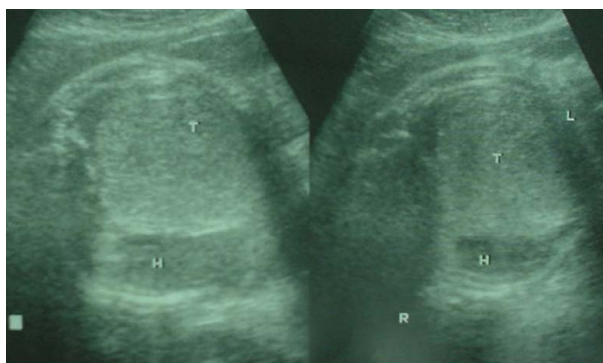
Prenatal ultrasound shows that the fetal heart (H) has been pushed to the right side of the thoracic cavity and a left thoracic tumor (T) was suspected.
